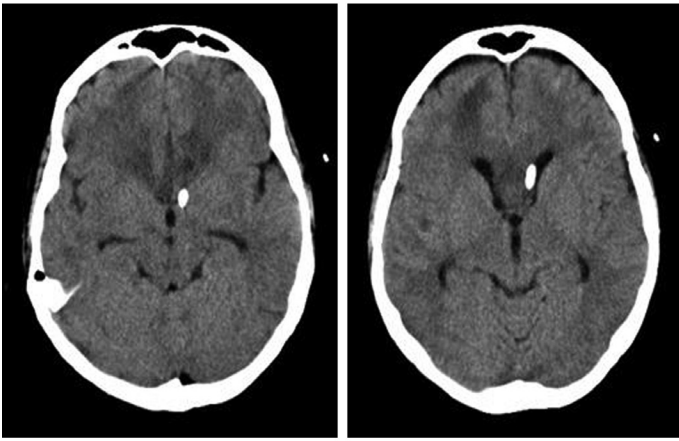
Non-contrast Head CT. CT 17 days later showing resolving global cerebral edema and left frontal EVD with bifrontal white matter changes from EVD placement.
